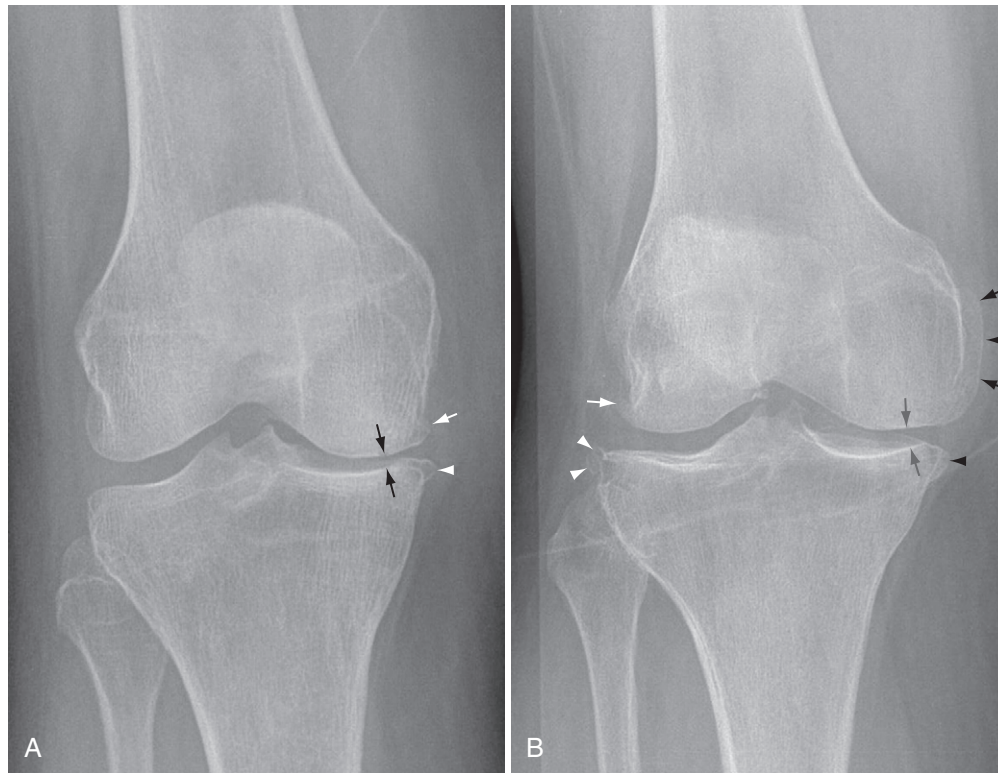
Examples of semiquantitative radiographic assessment with use of the Kellgren-Lawrence and Osteoarthritis Research Society International (OARSI) grading schemes. A, Kellgren-Lawrence grade 3. No lateral femoral and tibial osteophytes are seen (OARSI grade 0). A medial femoral osteophyte: OARSI grade 1 (white arrow); a medial tibial osteophyte: OARSI grade 2 (white arrowhead); lateral tibiofemoral joint-space width: OARSI grade 0; and medial tibiofemoral joint-space narrowing: OARSI grade 2 (black arrows) are depicted. B, Kellgren-Lawrence grade 2. A lateral femoral osteophyte: OARSI grade 2 (white arrow); a lateral tibial osteophyte: OARSI grade 2 (white arrowheads); a medial femoral osteophyte: OARSI grade 3 (short black arrows); a medial tibial osteophyte: OARSI grade 2 (black arrowhead); a normal lateral tibiofemoral joint-space width: OARSI grade 0; and medial tibiofemoral joint-space width: OARSI grade 1 (long black arrows) are shown. (From Guermazi A, Hunter DJ, Roemer FW: Plain radiography and magnetic resonance imaging diagnostics in osteoarthritis: validated staging and scoring, *J Bone Joint Surg Am* 91(Suppl 1):54–62, 2009.)
